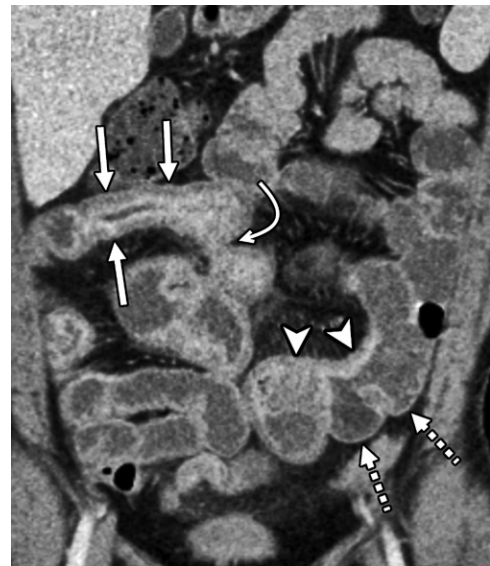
Moderate wall thickening (>5–9 mm). Coronal contrast-enhanced CT enterographic image with neutral oral contrast material shows moderate small bowel wall thickening with stratified mural hyperenhancement and luminal narrowing (solid straight arrows), consistent with active inflammatory Crohn disease with luminal narrowing. There is an enteroenteric fistula (curved arrow) at the proximal end of this bowel segment. In a different small bowel segment, there are sacculations (dashed arrows) along the antimesenteric border caused by asymmetric bowel wall inflammation (arrowheads) along the mesenteric wall.
